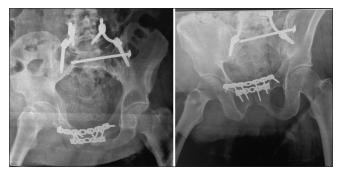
Radiographic series at 6-month follow-up showing fracture consolidation.
